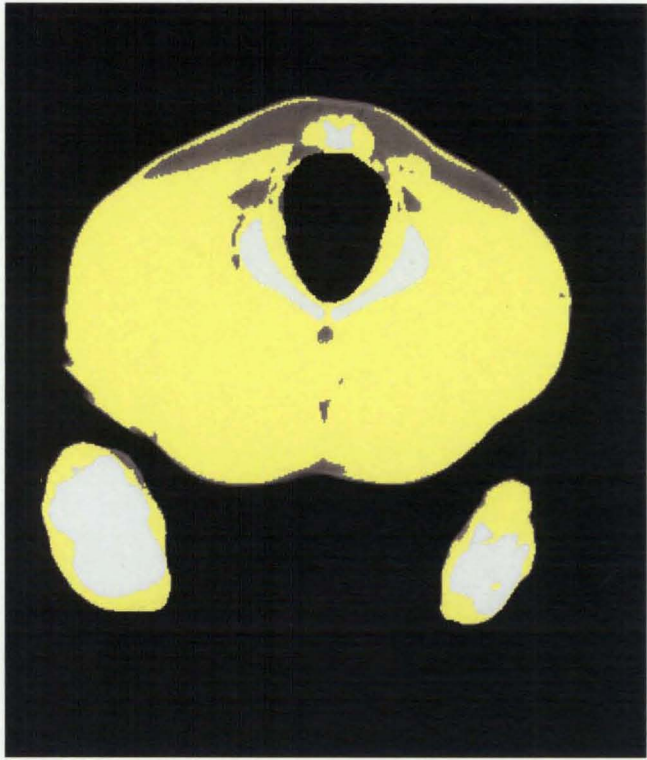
CT image with pixels in the lean (121-223) grey scale range. About 75 % of total image pixels are highlighted
